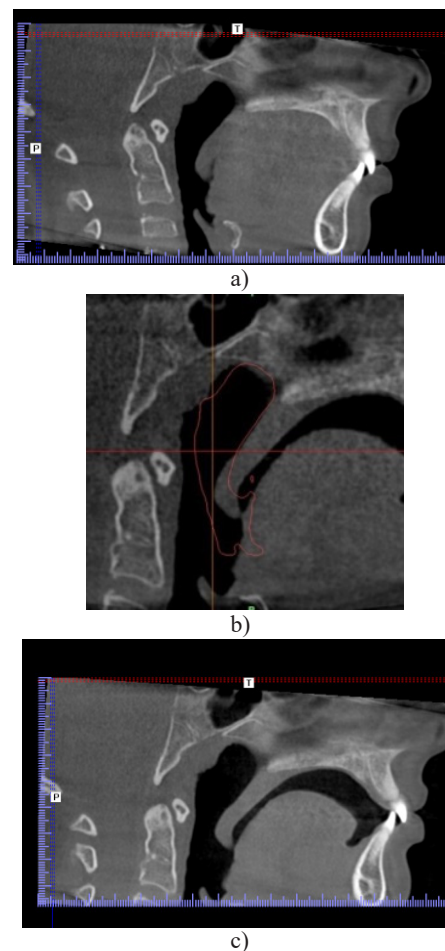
Coronary section of a cone-beam computed tomogram of patient C. airways, before (a) and after treatment (b), overlay of the airway profile before and after treatment (c)
